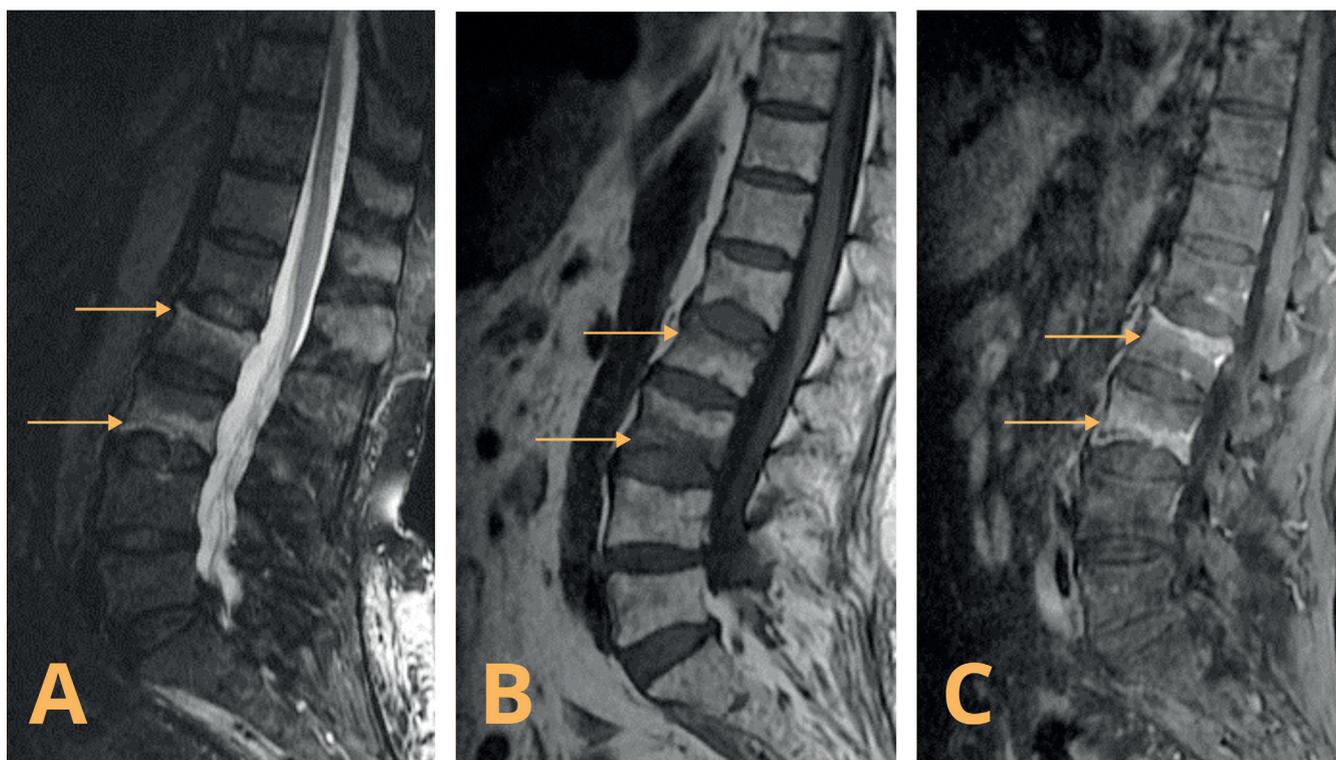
Sagittal T2-weighted fat-suppressed (A), T1-weighted (B) and T1-weighted fat-suppressed contrast-enhanced (C) magnetic resonance (MR) images of the lumbar spine in a patient with low back pain. In the upper part of the L2 and the lower part of the L3 vertebral bodies, there are areas of hyperintensity on a T2-weighted image and hypointensity on a T1-weighted image, enhancing after contrast administration (arrows), which are compatible with Modic type 1 degenerative changes
